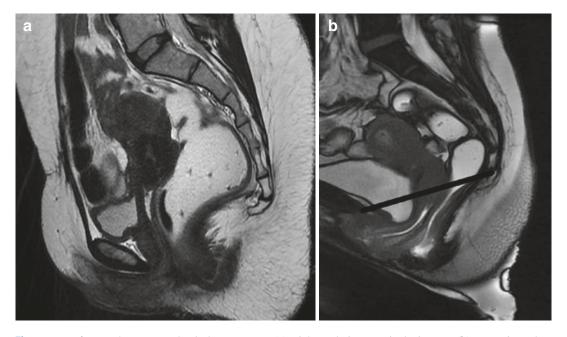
Defecography at rest and Valsalva maneuver. (a) High-resolution – sagittal T2 – rest. (b) Dynamic study – Valsalva maneuver: Descent of the bladder, urethra, vagina, and anorectal junction after evacuation of ultrasound gel
